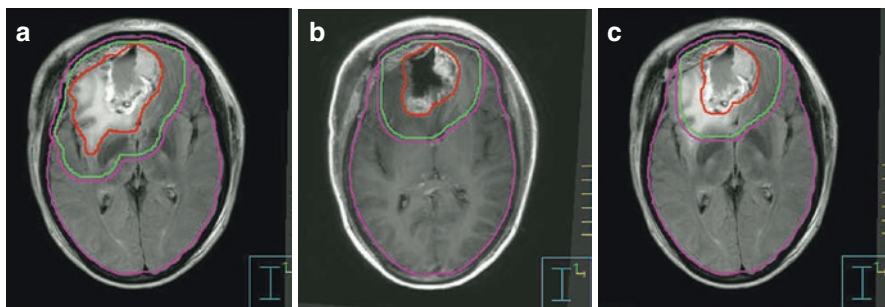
(a) The target volume definition for glioblastomas according to the CCG-943 study and most commonly used in US centers. The *red line* depicts the extent of the primary postsurgical tumor bed and associated edema (gross tumor volume, GTV) on the appropriate sequence of a dedicated volumetric planning MRI scan. This target volume is then increased by an institutional three-dimensional margin of 2–2.5 cm (*green line*) limiting/editing the volume by any barriers of natural spread (clinical target volume, CTV). Finally a margin of 0.3–0.5 cm (*pink line*) is added to form the final planning target volume (PTV) which takes into account spatial variations of the target volume due to setup uncertainties during a course of daily radical radiotherapy. This PTV receives usually a total dose of 45–46 Gy. (b) Using a shrinking field technique (according to the CCG-943 guidelines) following 45–46 Gy patients receive a boost to the primary postoperative tumor bed and/or any areas of visible macroscopic contrast enhancing tumor (GTV, *red line*) outlined on a fused post-contrast T1-weighted volumetric sequence. This target volume is then increased by an institutional three-dimensional margin of 2–2.5 cm (*green line*) limiting/editing the volume by any barriers of natural spread (clinical target volume, CTV). Finally a margin of 0.3–0.5 cm (*pink line*) is added to form the final PTV. The PTV receives a further dose increase to the final prescription dose of 54–60 Gy depending on local institutional protocols. In contrast to many US sites this GTV/CTV/PTV is used in most European centers as the primary target volume using a single phase approach to the prescription dose of 54–60 Gy. At our own institution we have been using for more than two decades—compared to the published literature—smaller margins without detriment to clinical outcome. Our institutional GTV to CTV margin for high-grade gliomas is 1.7 cm and the CTV to PTV margin 0.3 cm and are depicted in (a)–(c). (c) This figure depicts the target volumes as defined in (b) transferred to the fused MRI planning sequence visualizing the tumor bed, postoperative changes and remaining peri-tumoral edema. It is highlighting that a target volume definition as used in many European centers does cover most of the remaining edema within the defined CTV/PTV albeit not completely. It is unlikely that any future clinical trials will prospectively assess the potential differences between these two different radiotherapeutic approaches either with respect to local control or toxicity. Thus the choice of the target volume definition used for glioblastomas will remain at the discretion of local services
